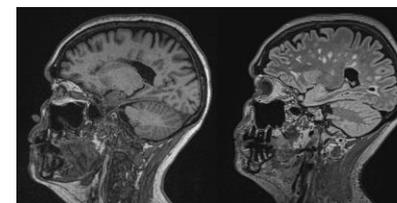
Example 3D high-resolution T₁-weighted (left) and T₂-FLAIR (right) images from an MS patient in the imaging cohort. These images are representative of the standardized MS MRI protocol.
